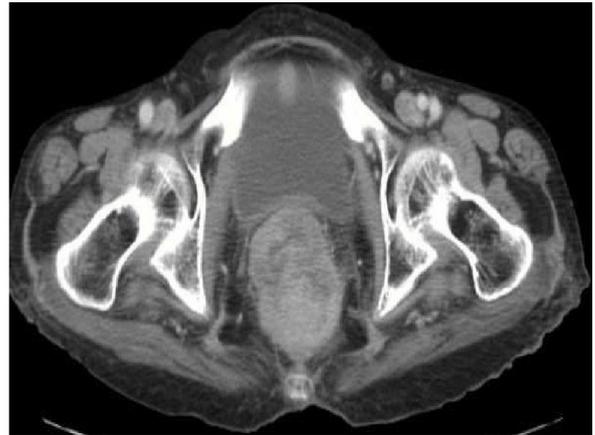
(a) CT- Carcinoma Rectum infiltrating cervix
